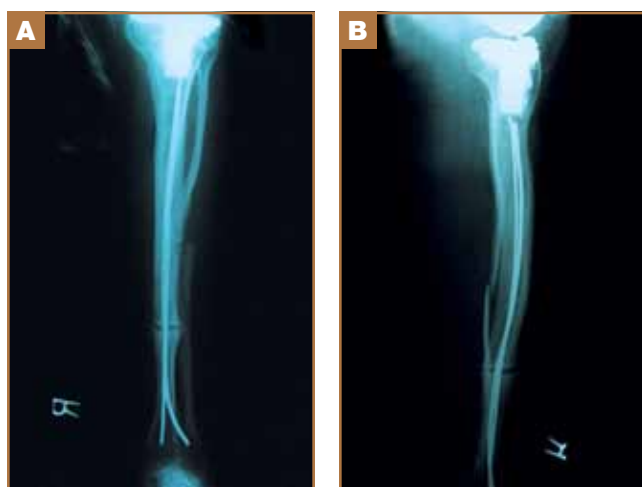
AP (A) and lateral (B) radiographs of right tibia status post tibial osteotomy and retrograde flexible nails with minimal callous formation.
